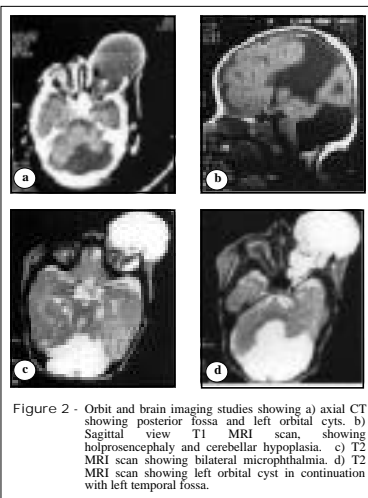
Orbit and brain imaging studies showing a) axial CT showing posterior fossa and left orbital cysts. b) Sagittal view T1 MRI scan, showing holoprosencephaly and cerebellar hypoplasia. c) T2 MRI scan showing bilateral microphthalmia. d) T2 MRI scan showing left orbital cyst in continuation with left temporal fossa.
